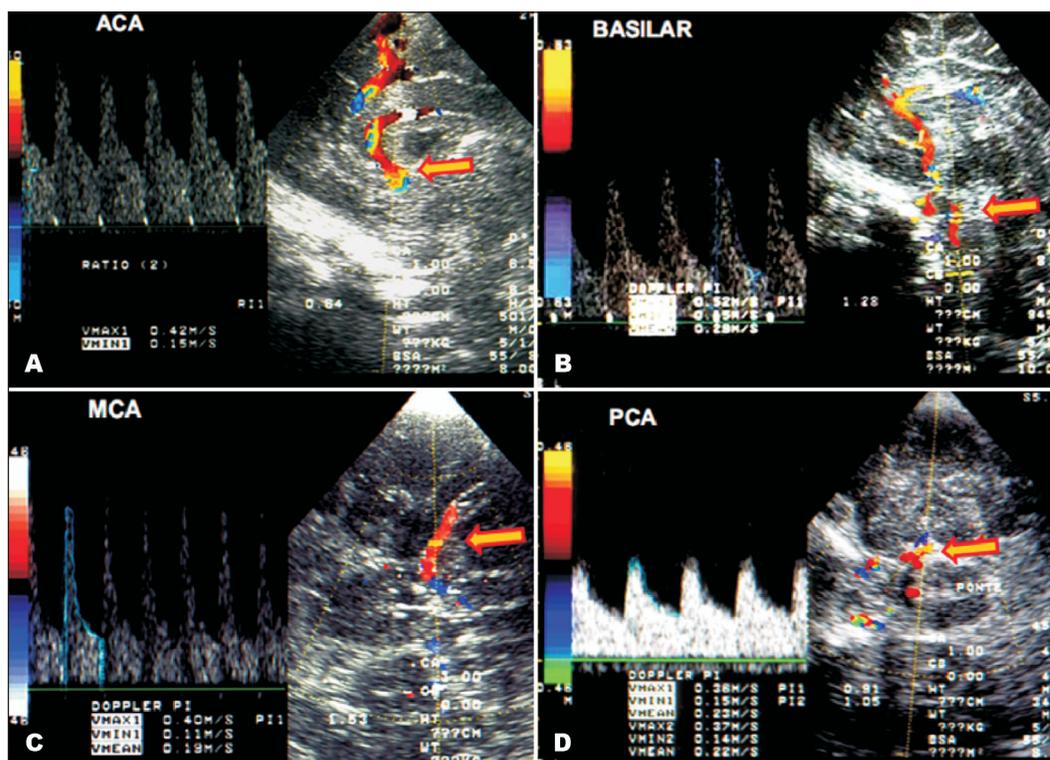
[A] Midline sagittal uplex Doppler scan through anterior fontanel showing on the right the color image of anterior cerebral artery (arrow) and on the left the spectral curve, and in [B] basilar artery (arrow). [C] Transaxial Duplex Doppler scan through temporal bone showing on the right the color image of M1 segment of middle cerebral artery (arrow) and on the left the spectral curve and in [D] posterior cerebral artery (arrow).
